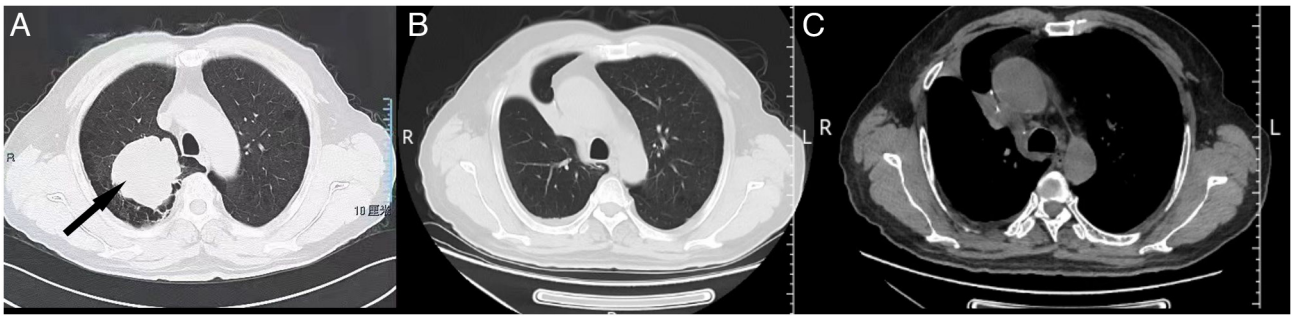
Chest CT scans of a 57-year-old male patient prior to and after surgery. (A) Preoperative chest CT displaying a mass in the upper lobe of the right lung. The black arrow indicates the mass. (B) The postoperative chest CT indicated no primary tumor in both lungs or hilum. (C) The postoperative CT revealing no obviously enlarged lymph nodes in the mediastinum. CT, computed tomography.
